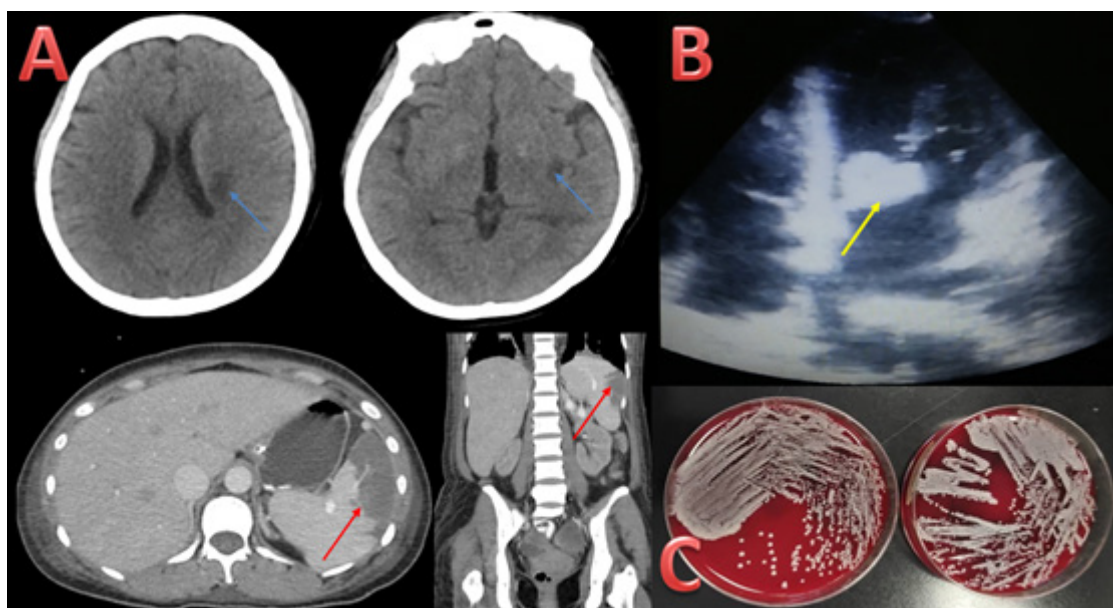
(A) CT brain shows ill-defined hypodensities (blue arrows) at the left corona radiata and left external capsule (blue arrow) in keeping recent infarcts. Differential diagnosis includes septic emboli to the brain. CT abdomen shows well-defined wedge shape hypodensity (red arrows) at the peripheral aspect of the mid-pole spleen (blue arrow) in keeping with splenic infarct. (B) Transthoracic echocardiogram shows large vegetation on the mitral valve (red arrow). (C) Greyish-white non-haemolytic colonies of *Corynebacterium simulans* on blood agar (using Vitek 2 Automated System)
